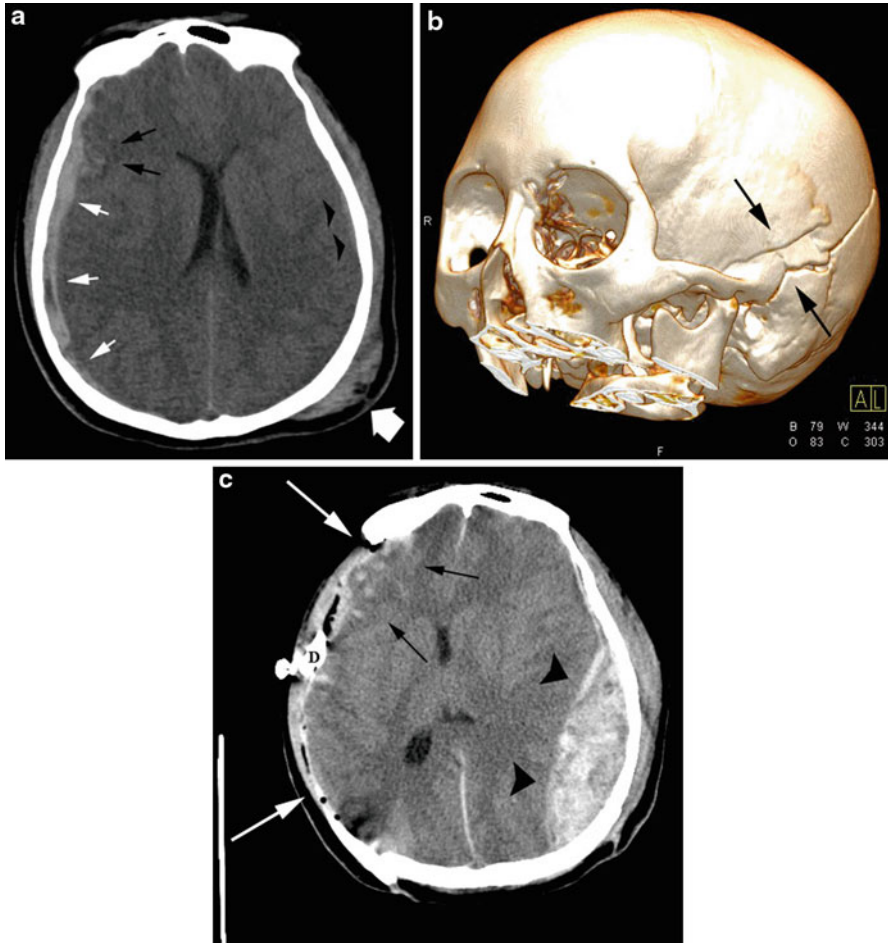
Intracranial injury requiring emergent decompression. 14-year-old female riding on the hood of a car (“car surfing”) who fell off at high speed. The adult driver was subsequently charged with child endangerment. The initial noncontrast CT demonstrates an acute right-sided subdural hematoma (*white arrows*), right frontal intraparenchymal hemorrhagic contusions (*black arrows*), and midline shift to the left (*a*). Notice a subtle left-sided extra-axial collection which is lentiform in shape consistent with an epidural hematoma (*black arrowheads*). There is a left parietal scalp hematoma indicating the site of impact (*large white arrow*). A 3D reconstruction of the skull (*b*) demonstrates a comminuted fracture of the left temporal bone (*black arrows*). The patient was taken to the operating room for a right decompressive craniotomy; however, in the recovery room the patient’s condition deteriorated, and an emergent follow-up CT (*c*) was obtained which showed rapid interval enlargement of the left-sided epidural hematoma (*black arrowheads*) with partial effacement of the ventricular system and midline shift to the right. Notice the right frontal parietal craniectomy (*white arrows*). Also the hemorrhagic contusions (*black arrows*) are more prominent. A surgical drain and overlying skin staples are partially seen (*D*). The patient returned to the OR for emergent decompression of the left-sided epidural hematoma
